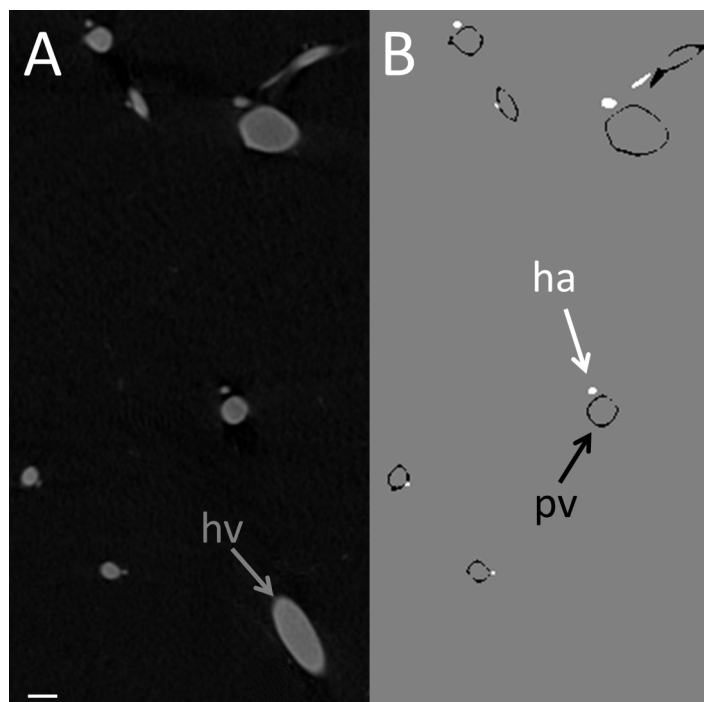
Panel A: cross-sectional tomographic slice of original gray scale CT image data set for *S1*. Panel B: the hepatic vein was removed by the segmentation method, and the portal vein mask subtracted. The scale bar in the bottom left corner is 0.3mm in length, and the hepatic artery (which follows alongside the portal vein throughout the liver) is clearly distinguished (solid white) from not only the background, but also its concomitant vessel system (the portal vein).
